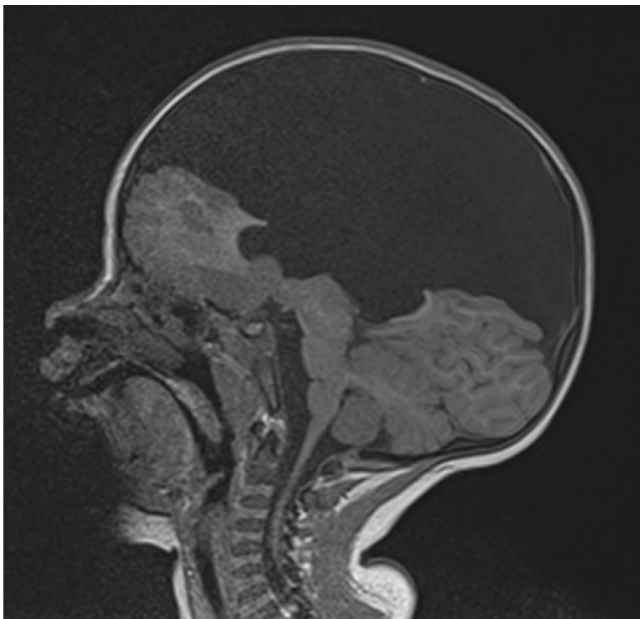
MRI brain demonstrates obstructive hydrocephalus secondary to Atresia of the Aqueduct of Sylvius in sagittal T1-weighted image.
